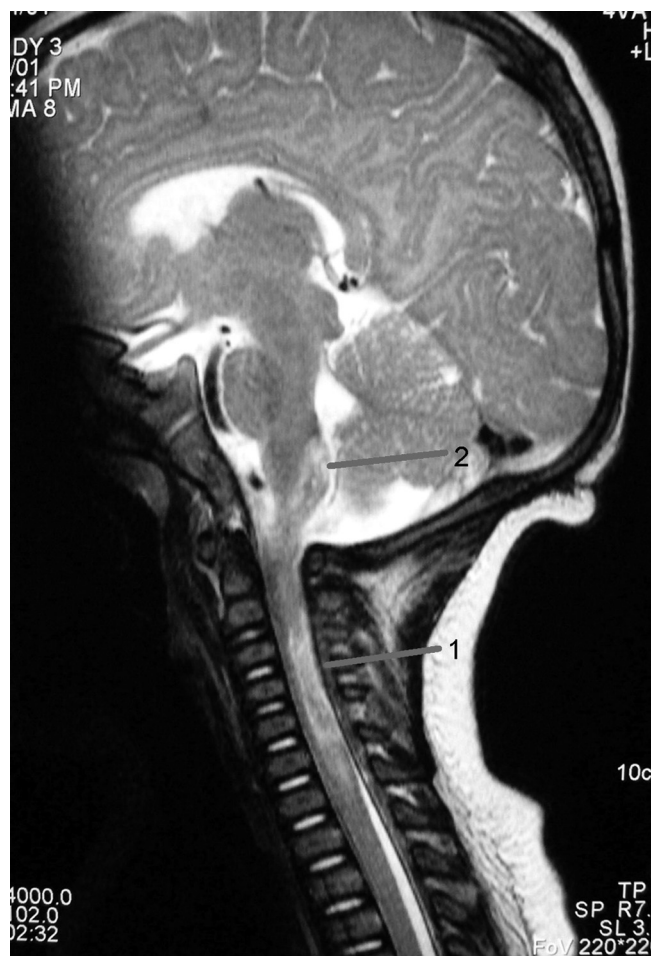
Sagittal T2 MRI of a 6-month-old infant with central cord syndrome. High density of acute hemorrhage extends from the upper posterior medulla (line 2) to C7. The cord is swollen (line 1).
